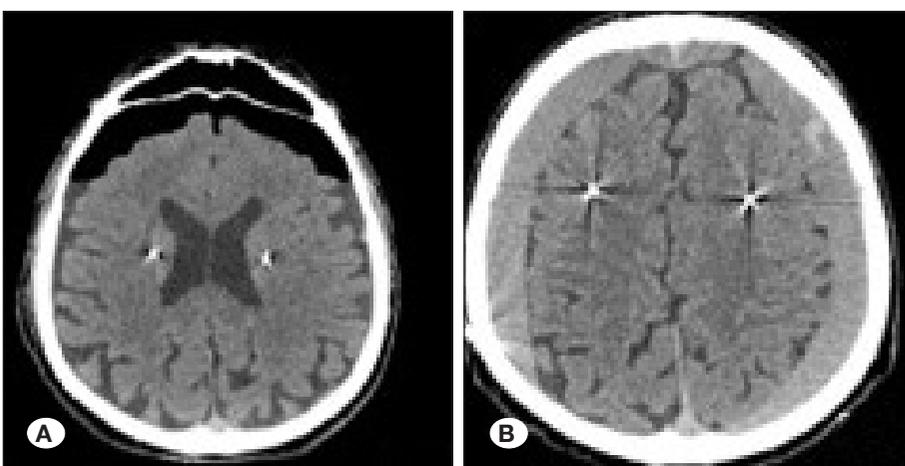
A) An axial CT scan slice presenting pneumocephalus in the bilateral frontal area. B) An axial CT scan slice showing bilateral chronic subdural hemorrhage.
